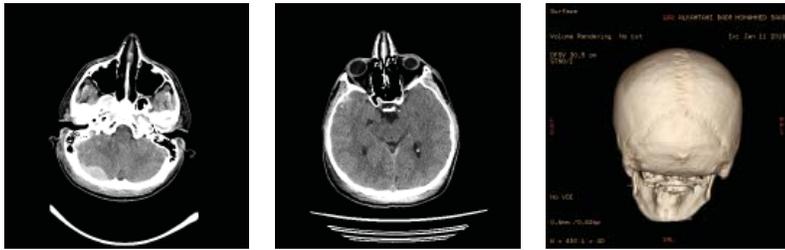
The initial CT Brain of case No.1. (a) shows a small right retro cerebellar extradural hematoma. (b) shows no associated supratentorial hydrocephalus and a small right temporal hemorrhagic contusion. (c) 3D bone reconstruction showing no bone fracture overlying the hematoma
